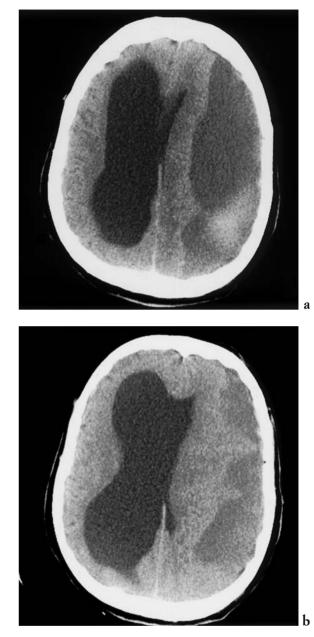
Subdural haematoma. Axial CT reveals and unusual appearing left frontoparietal subdural haematoma with a hyperdense acute haemorrhagic component layering posteriorly. The left lateral ventricle is compressed by the haematoma and the contralateral lateral ventricle is dilated. [a), b) axial CT].
